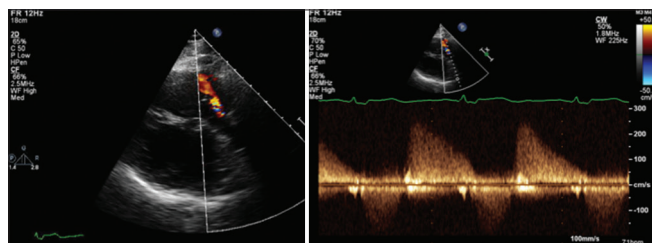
Parasternal short axis view (left) and the Doppler interrogation (right) of the native pulmonary tract demonstrating the moderate-to-severe regurgitation by color echocardiography
